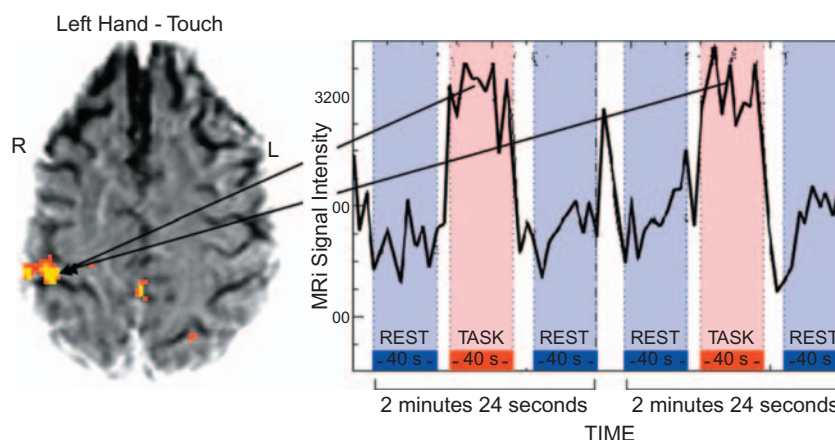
How the BOLD signal cycles on and off. The basic physics of BOLD requires a high magnetic field to be turned on and off frequently to detect the radio frequency changes due to spin changes in oxygen atoms. Because cognitive tasks occur over seconds and fractions of seconds, a common method is to alternate Task and Rest conditions every half minute or so (in this case, 40 seconds per phase). This allows for excellent within-subject control. On the left, the functional signal (i.e. BOLD) is superimposed on a structural brain scan (using MRI). All brain images superimpose the task-related activity upon brain structure, and average out background activity. *Source: Robinson, 2004.*
